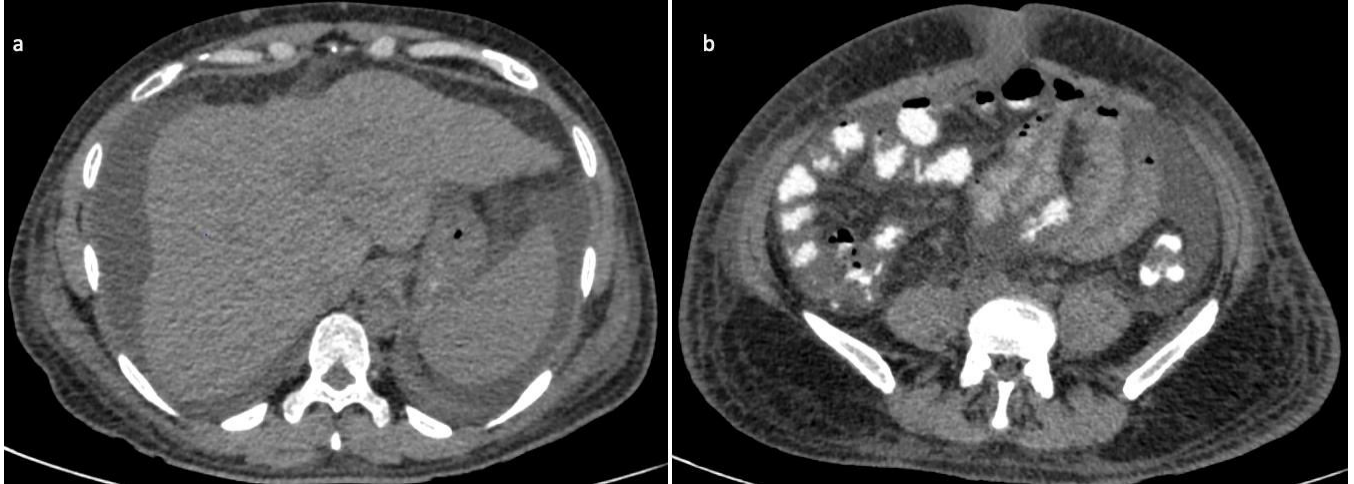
Plain axial CT abdomen images reveal shrunken right lobe of liver with irregular hepatic surface and ascites.
